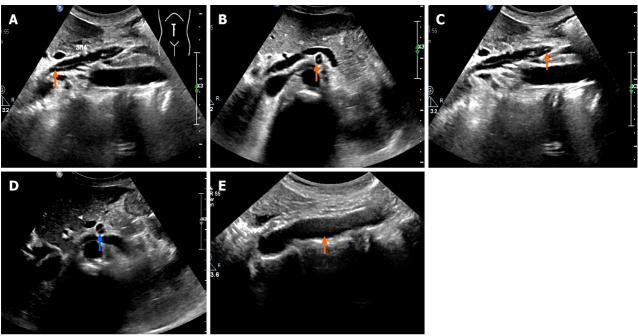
Gray-scale ultrasound showed the superior mesenteric artery dissection and abdominal aorta. A: Ultrasonic longitudinal view demonstrated the opening of superior mesenteric artery dissection (SISMAD) (orange arrow); B: Transverse view demonstrated the opening of SISMAD (orange arrow); C: Ultrasonic longitudinal view showed the distal end of SISMAD (orange arrow); D: Transverse view showed the distal end of SISMAD (blue arrow); E: No abnormal echo was observed in the abdominal aortic lumen (orange arrow).
